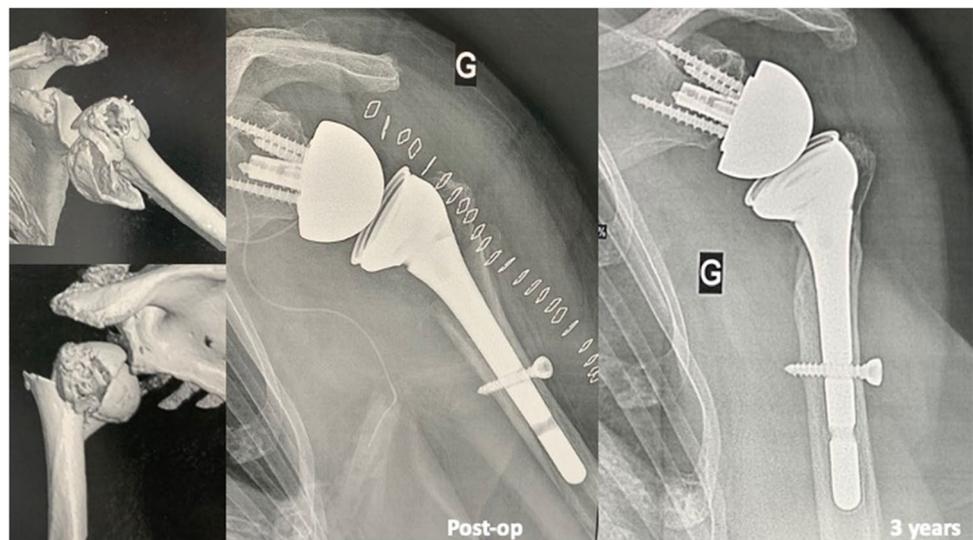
Trauma case: 4 parts fracture with humeral head split treated with locked Humelock Reversed. X-rays at 3 months and 3-year follow-up: healing of the tuberosity is seen at the proximal stem, and no stress shielding is seen around the distal screws fixation
